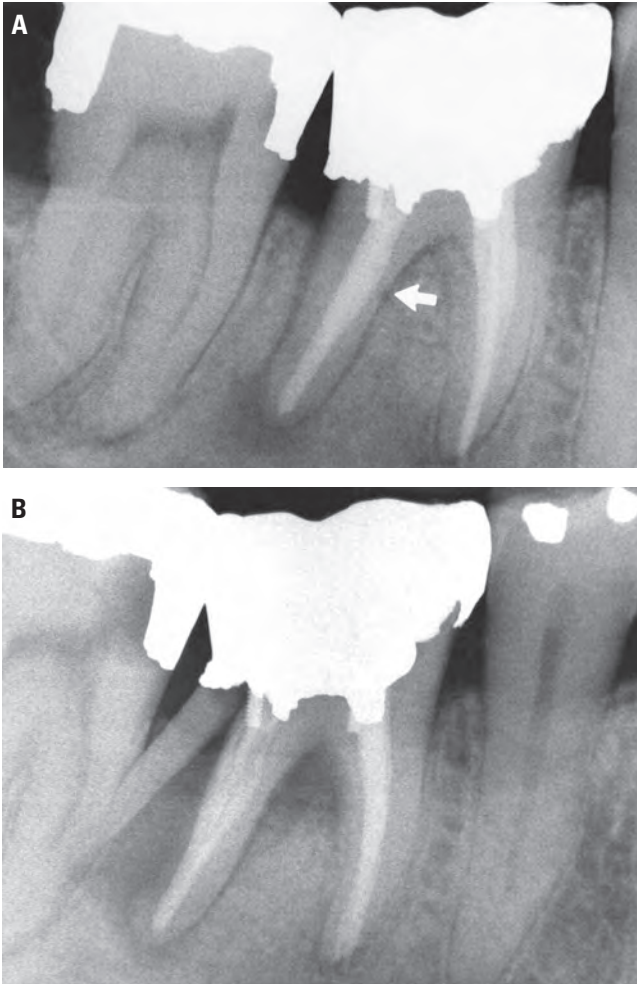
Vertical root fracture associated with overzealous canal preparation. A, Postoperative radiograph shows distal canals prepared and filled leaving a thin-walled root (*arrow*). B, Twelve months later, the patient reported with a vertical root fracture
